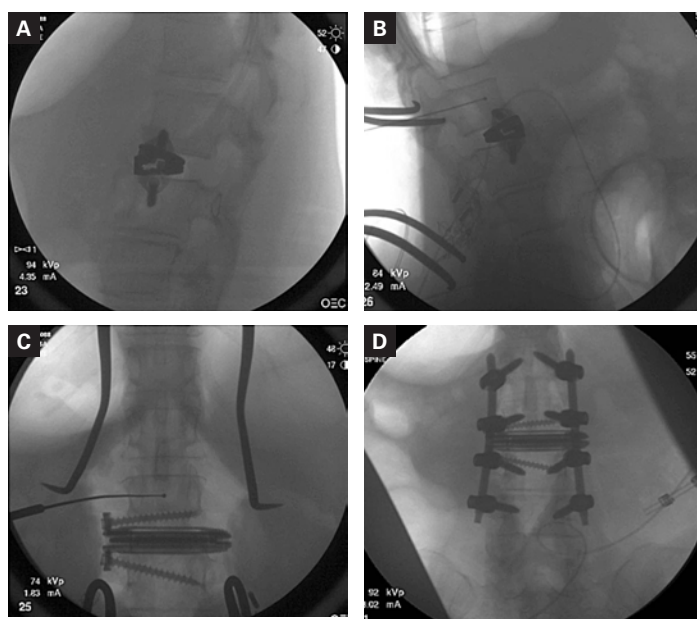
Intra-operative imaging. (A) Lateral intraoperative X-ray demonstrating placement of the expandable cage at the L2-L3 level prior to SPO, and (B) after the SPO. (C) AP intraoperative image prior to instrumented fusion, and (D) final AP status post final instrumentation.
